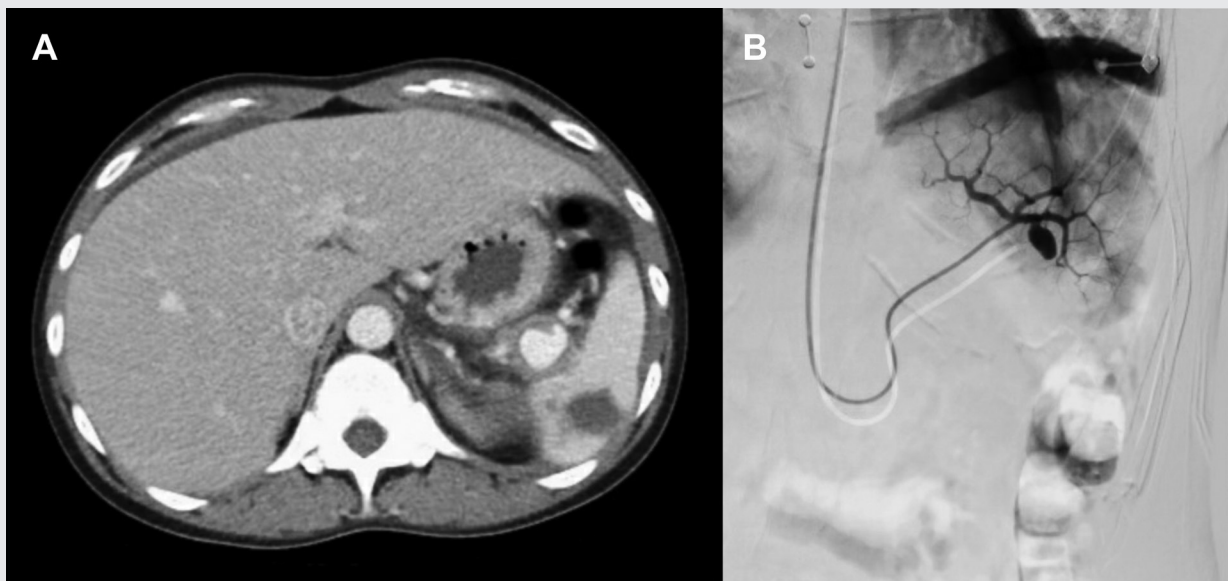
(A) CT angiography of the abdomen showing splenic pseudocyst and suspected splenic artery aneurysm. (B) Angiography showing saccular splenic artery aneurysm.
